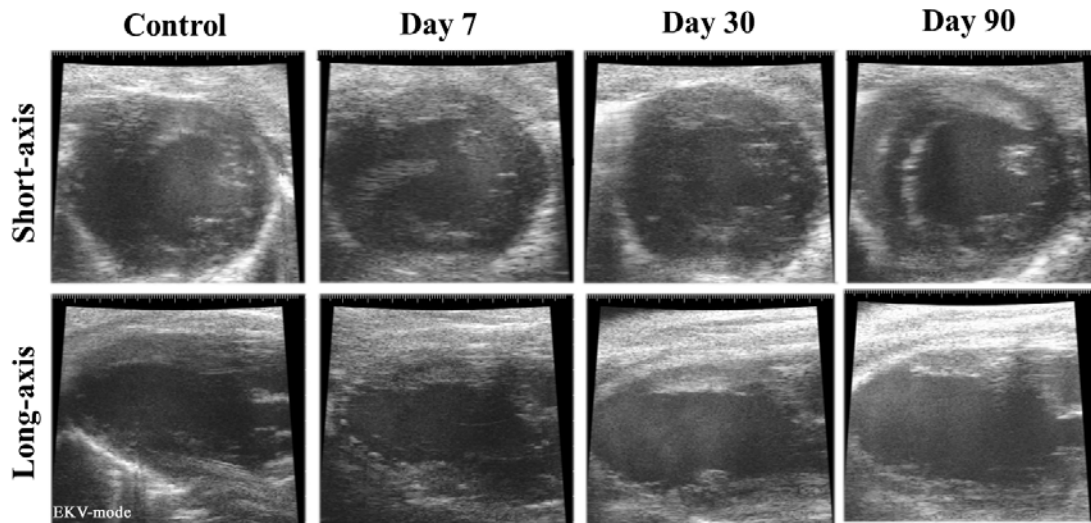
Visualization of the infarction. Sample images at baseline and 7, 30 and 90 days post-infarction. Upper row: Parasternal short-axis views. Lower row: Paraesternal long-axis views. The infarcted area is appreciated 7 days post-infarction and is located at the apical region. The evolution of the infarction results in progressive left ventricular remodeling.
